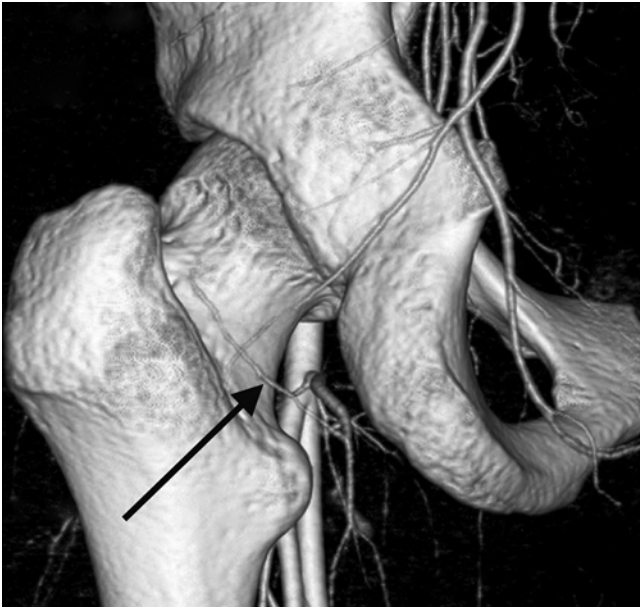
Volume rendering image of the angio-CT scans showing the deep branch of the medial femoral circumflex artery (arrow) from its bifurcation into the posterior superior nutrient arteries (Reproduced with permission and copyright © of the *British Editorial Society of Bone and Joint Surgery* [14])
